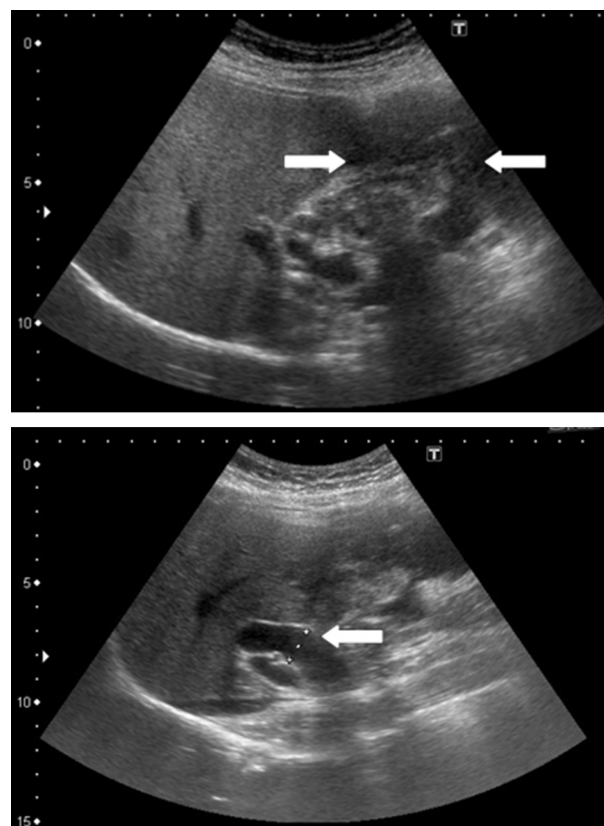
Abdominal ultrasonography showing one mixed echogenic tumor approximately 9.5 cm from the head of the gallbladder sac. The common bile duct was dilated to 1.4 cm.
